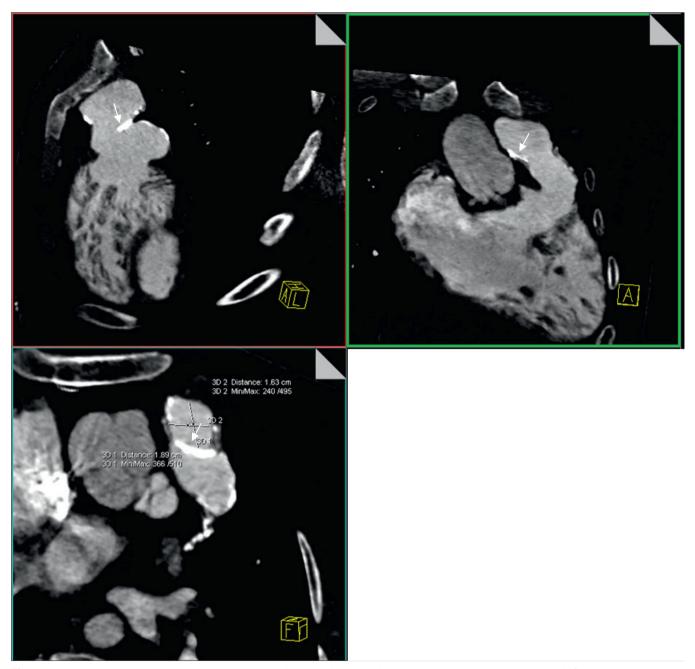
Computed tomography. Conduit connecting right ventricle (RV) with main pulmoanry artery (MPA) with calcifications (arrow)
